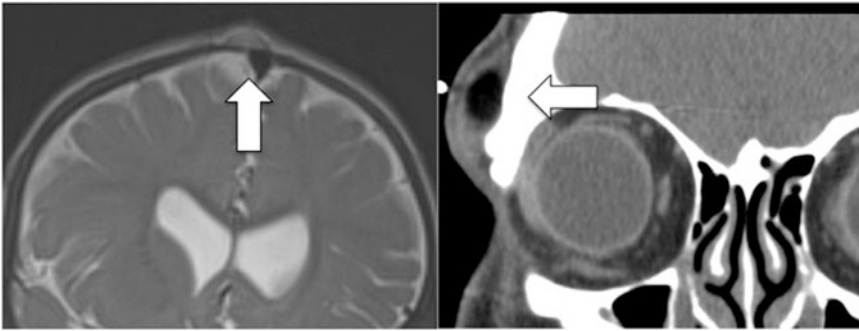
Dermoids: Anterior fontanel dermoid on coronal T2-weighted MRI (*left*) and periorbital dermoid on coronal-reformat computed tomography scan (*right*)
